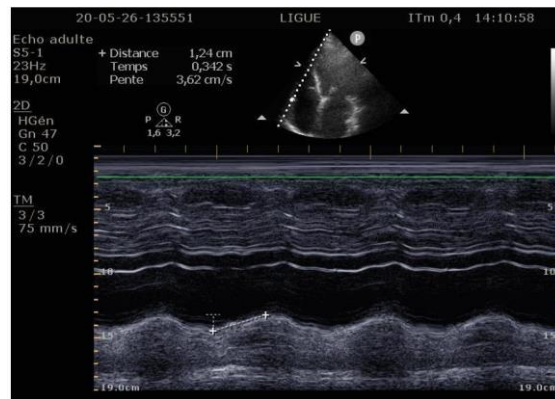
Echocardiographic image showing altered TAPSE in one of our patients
